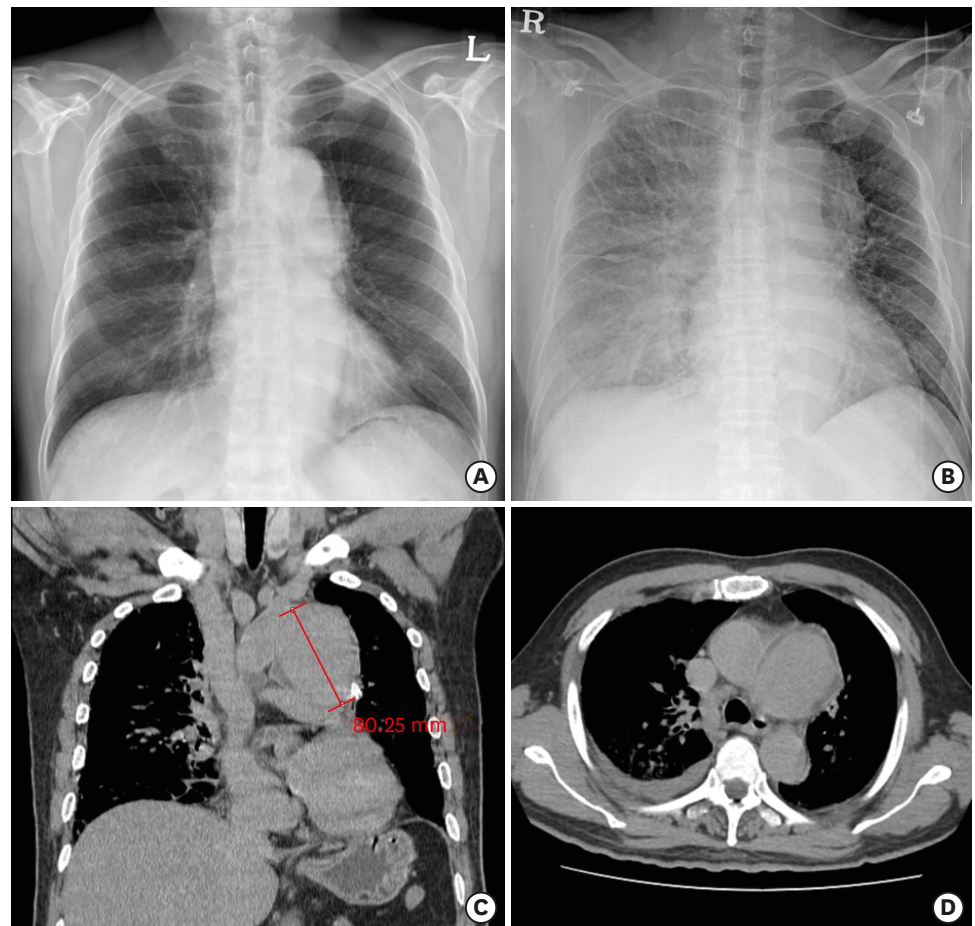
(A) Initial preoperative chest X-ray showing mild mediastinal widening. (B) Chest X-ray in the emergency unit showing exacerbation of mediastinal widening and haziness of the right lung. (C) Coronal section of pre-enhanced phase computed tomography showing the aortic arch aneurysm with a maximum diameter of 8.0 cm (D) Axial section of pre-enhanced phase computed tomography. White arrow indicates the saccular aneurysm.
